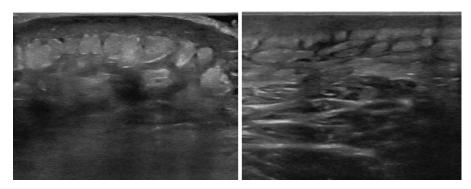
Point-of-care ultrasound demonstrating a cobblestone appearance consistent with cellulitis.
